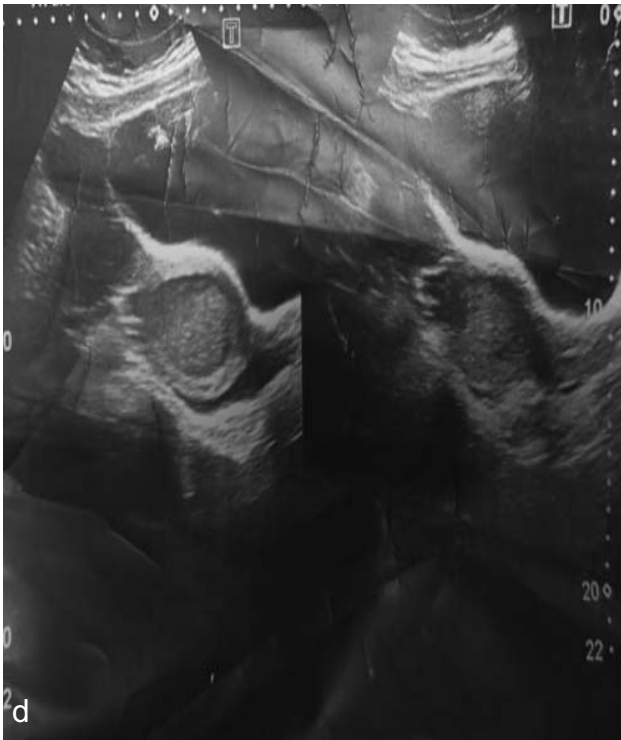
Ultrasound images of the same patient showing: Fluid filled interconnected cystic areas with incomplete septae sign seen in right adnexa representing hydrosalpinx. (A) Endometrial cavity distended with echogenic material representing blood, No communication of this cavity with cervix or vagina, minimal pelvic free fluid (B,C,D)
